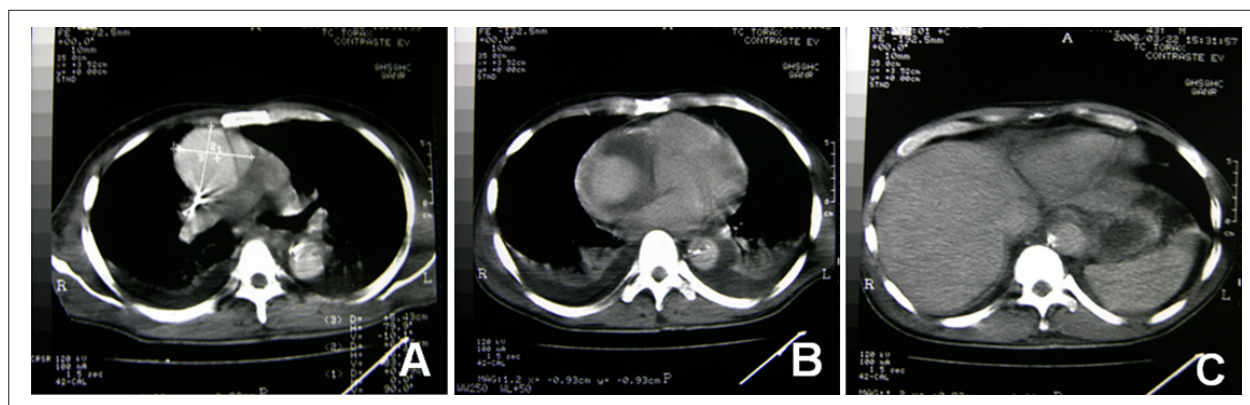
Chest CT scan revealing (A) ascending thoracic aortic aneurysm, with aortic dissection extending from the origin of the ascending segment to the thoracic aorta (B) to the lower third of the descending segment (C).
